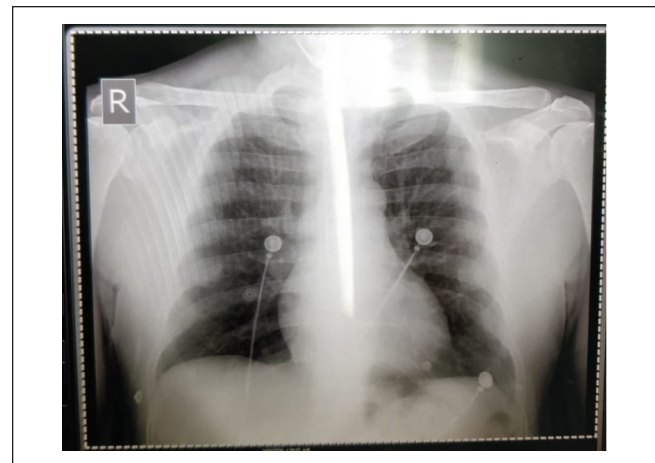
The patient's chest radiograph does not indicate any airspace disease that would be expected in coronavirus-2019 (COVID-19) infection.
